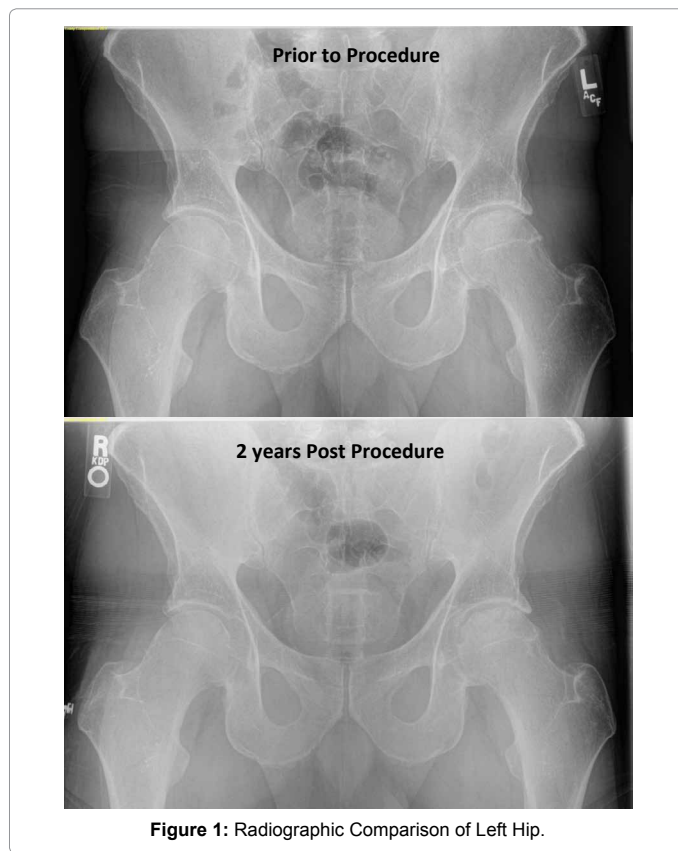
Radiographic Comparison of Left Hip.
